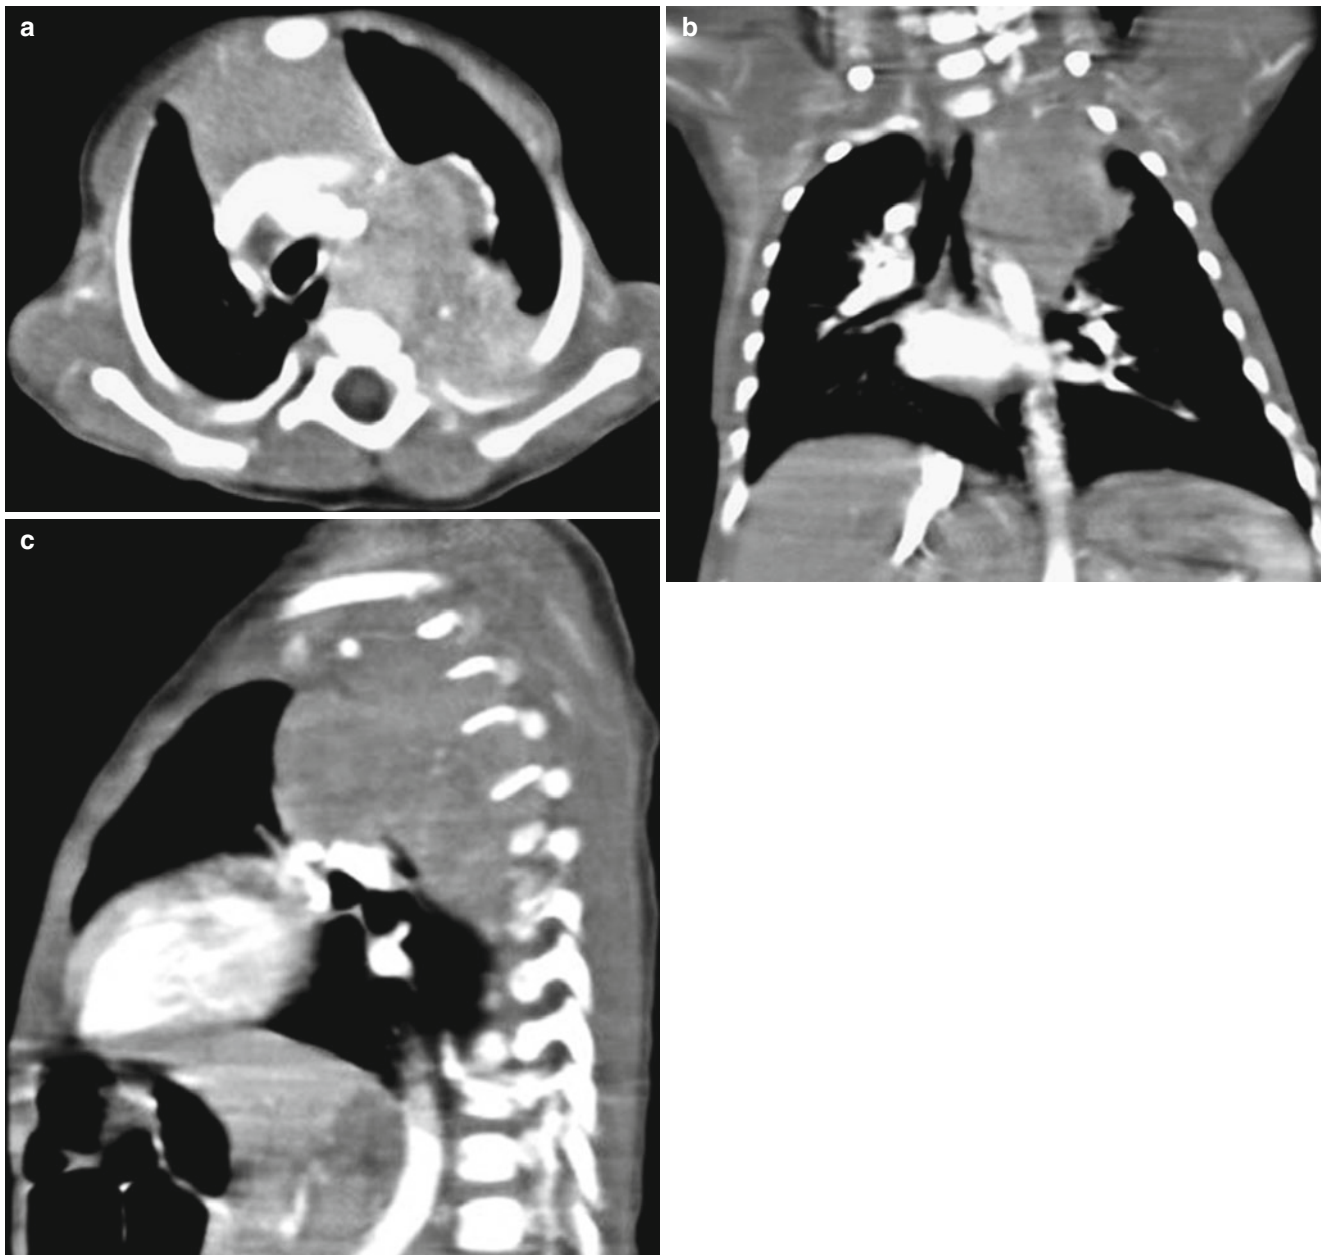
Neuroblastoma in an infant. (a) Axial contrast-enhanced CT shows a calcified left paraspinal soft tissue mass across the midline. (b, c) Coronal and sagittal reformation CT show the craniocaudal extent and the midline extension of this posterior mediastinal mass
